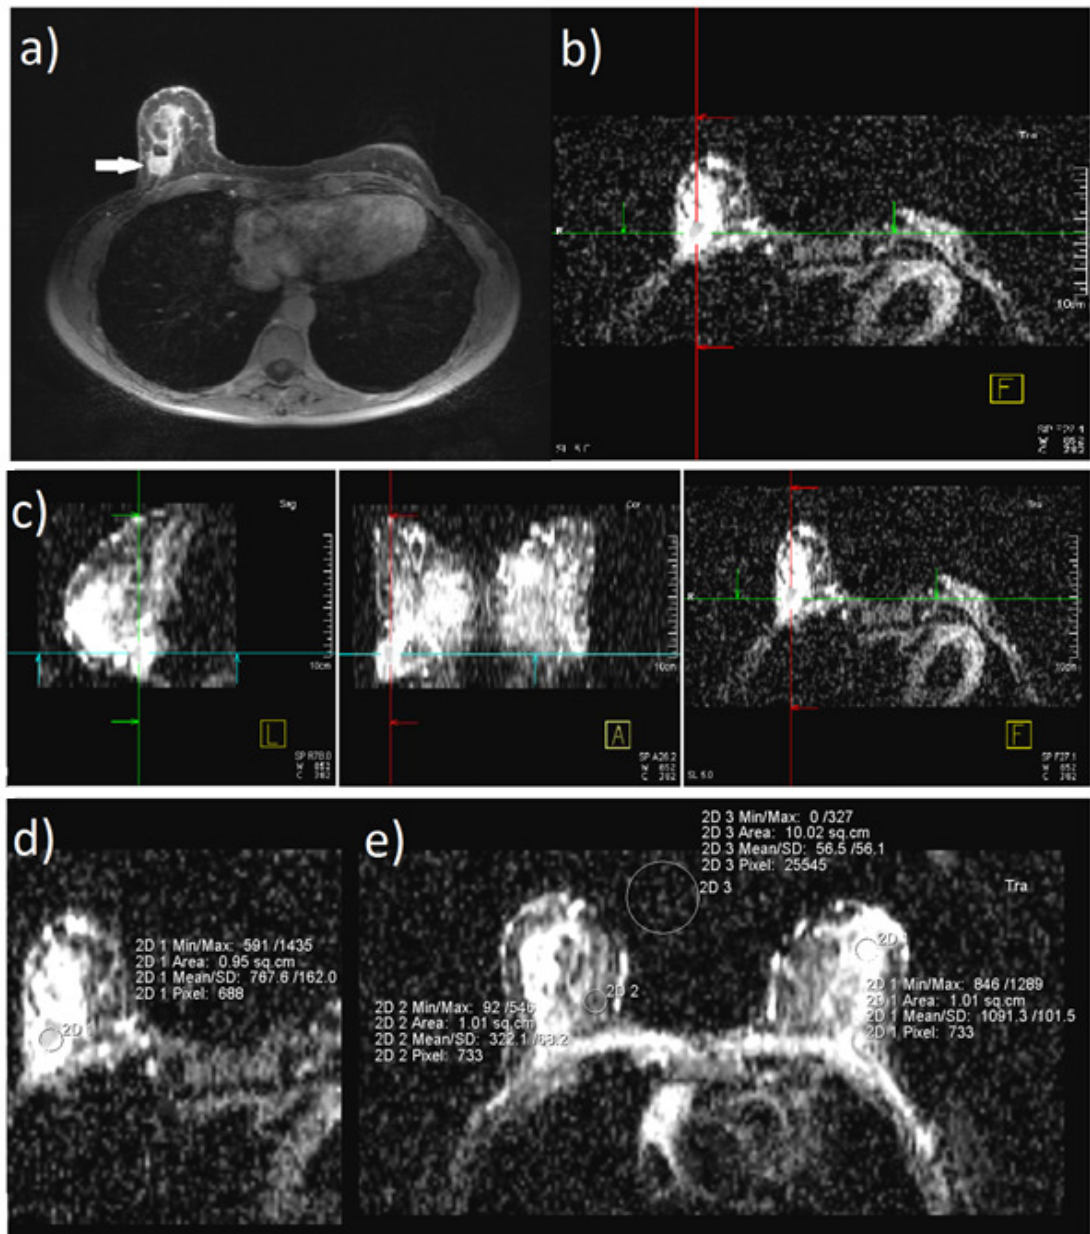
Example of ADC measurement. a) First lesions was localized in DCE-MR image (now shown with white arrow) and b) with the help of obtained coordinates its corresponding location was searched in ADC maps. c) ADC map could be visualized from three directions, *sagittal*, *coronal* and *transverse*. d) The ROI was drawn carefully into the lesion. e) Three reference ROIs were drawn into high intensity area, homogeneous tissue area and into the background (outside the patient).
